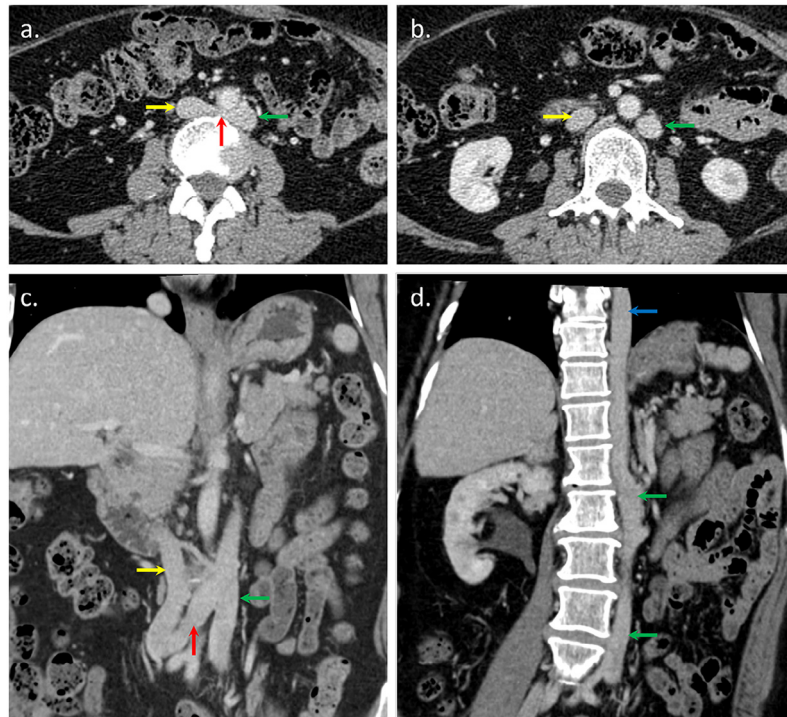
Contrast-enhanced axial computed tomography of the abdomen and pelvis (A, B) and coronal oblique reformations (C, D) demonstrate double IVC, with retroaortic communication (red arrows) between the right IVC (yellow arrows) and the left IVC (green arrows), the latter continuous with the enlarged hemiazygous vein (blue arrow). IVC, inferior vena cava.
